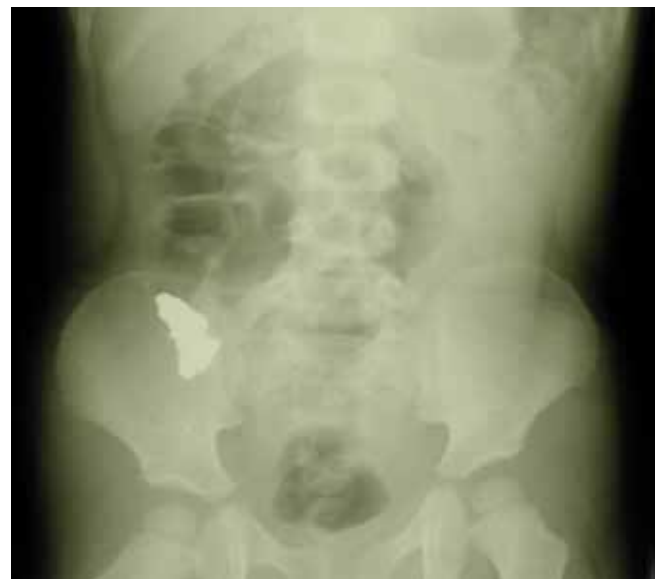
Abdominal X-ray: demonstrating a foreign body in the region of the ileo-caecal valve. There was no small bowel dilatation and there was air in the rectum.
